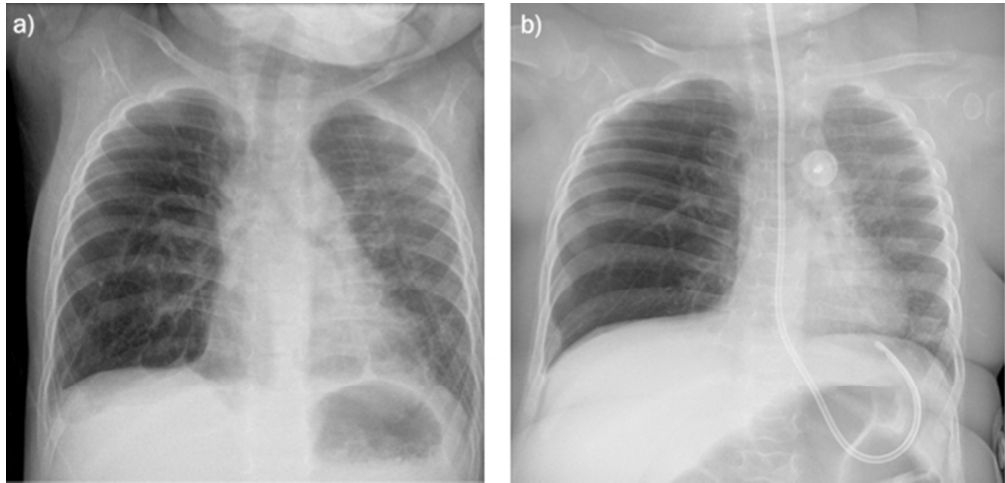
Serial chest radiographs from case 2 performed at (a) 8 months of age and (b) 15 months of age reveal progressive right sided hyperinflation, mediastinal shift to the left and diffuse ground glass opacification within the left lung.
